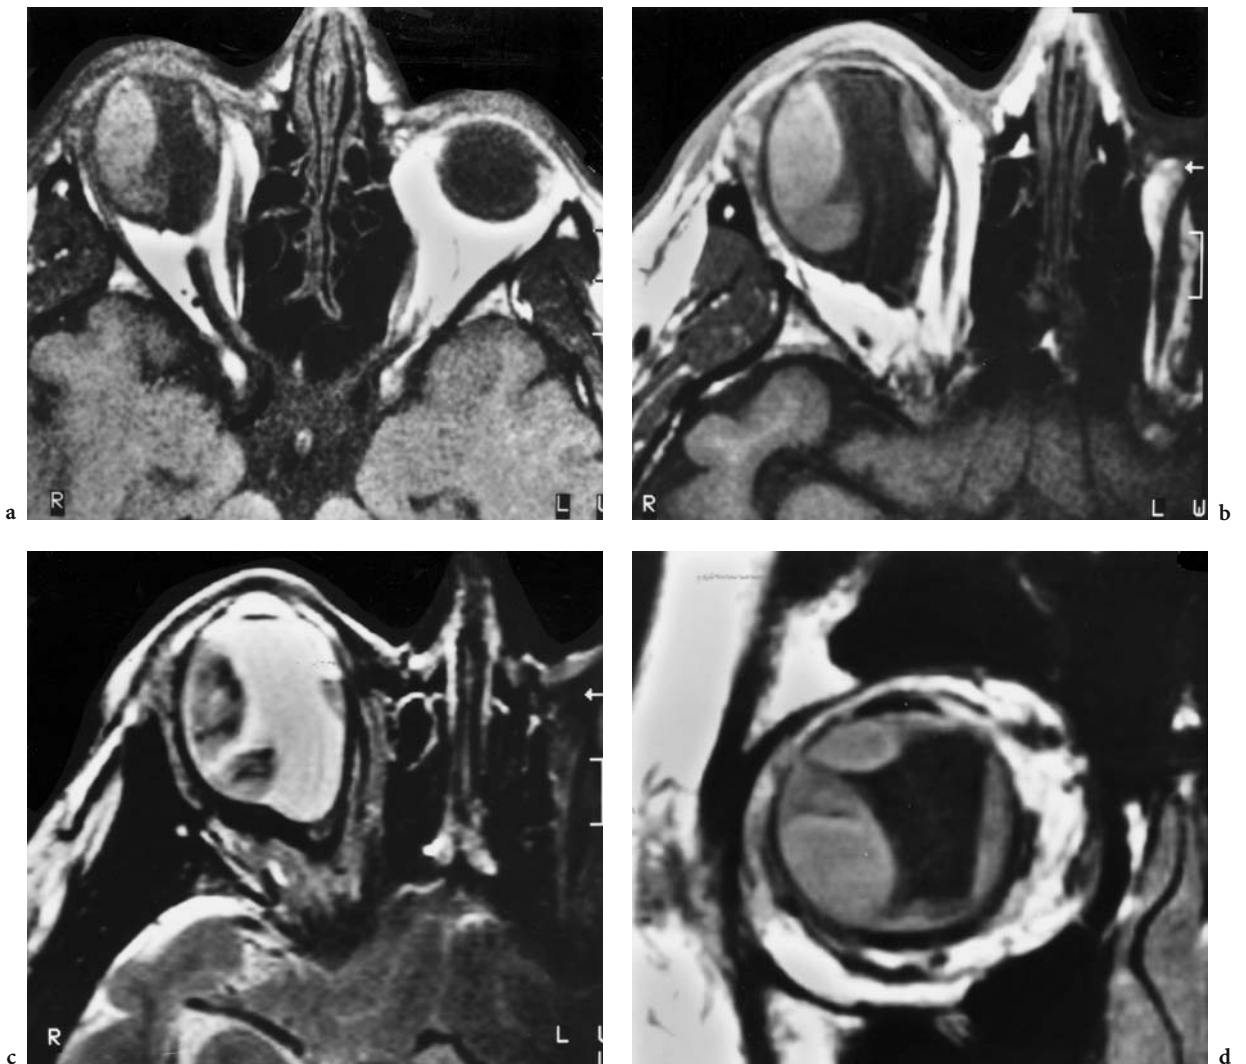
A 36-year-old woman with acute visual loss 1 day after intraocular operation. Diagnosis: subretinal hemorrhage. Axial MRI: a T1-weighted native image (head coil and focal magnification) with biconvex configured, medial and lateral subchoroidal hemorrhage. The low signal at the center of the lateral area represents fresh, intracellular hemoglobin, while sedimentation of blood particles is seen in the medial area. b Corresponding T2-weighted sequence (surface coil over both orbits and magnification) also demonstrates signal reduction due to the fresh hemorrhage. Note normal signal intensity of the intact vitreous body (*star*) in both acquisitions (T1-weighted: hypointense, T2-weighted: slightly hyperintense)
